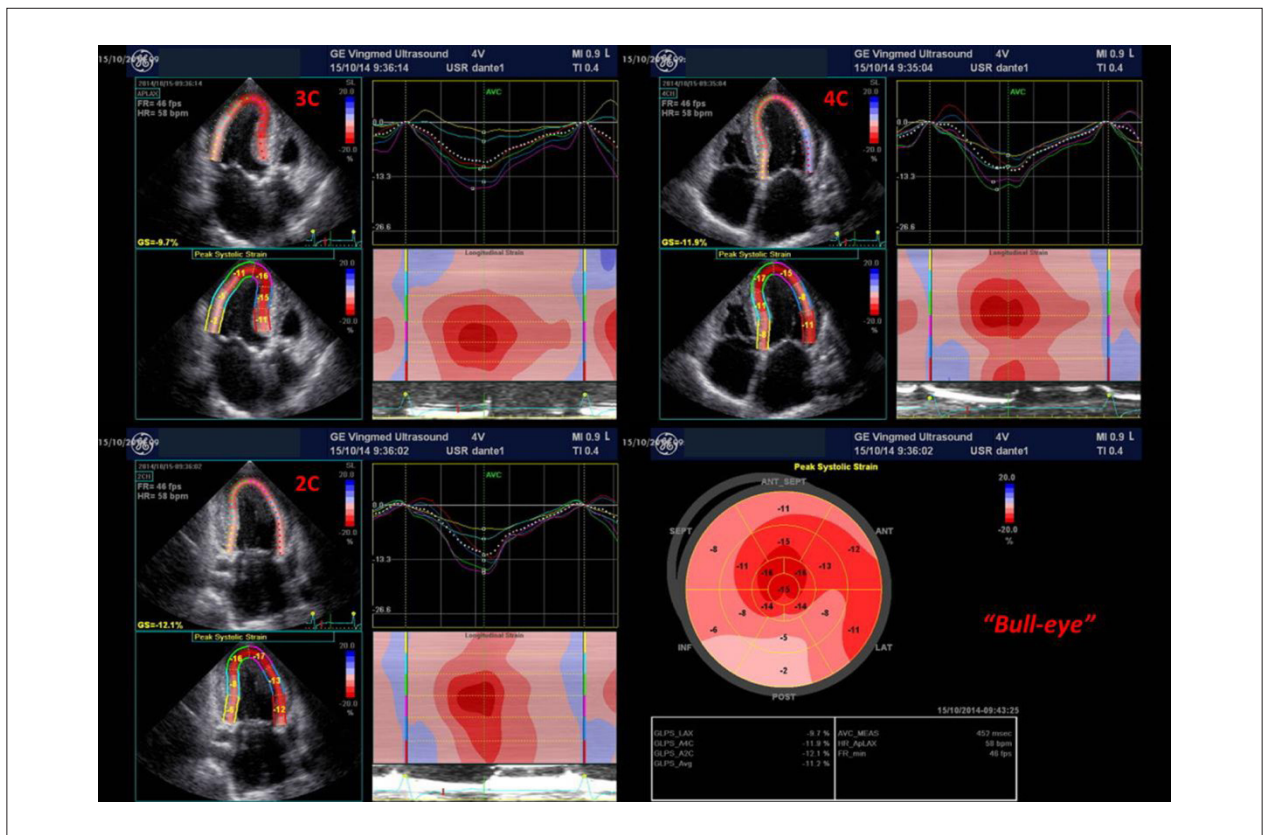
Example of a patient with severe aortic stenosis, normal left ventricular ejection fraction (68%) and reduced longitudinal strain. Parametric images and strain curves are observed by segment in apical three-chamber (3C), four chamber (4C) and two chamber (2C) views. In the right lower corner, we can see the bull-eye of the left ventricle, showing colors compatible with diffuse reduction of longitudinal strain. Photo given by Dr. David Le Bihan, IDPC.
